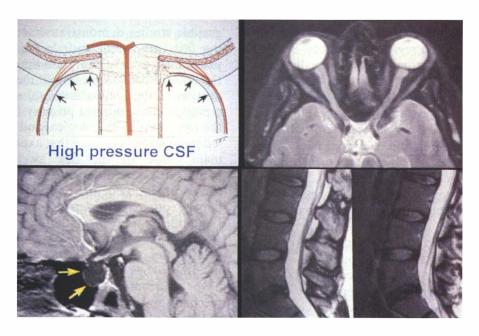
High CSF pressure and the optic nerve sheath. Top left: High CSF pressure distends the distal sheath and fluctuations in pressure can affect branches of the circle of Zinn. Top right: Distended sheath with distal dilatation, acting as an 'expansion vessel', shown on T2-weighted axial MRI scans. Bottom left: Distended pituitary fossa, containing CSF and termed the 'empty sella syndrome'. Bottom right: CSF in the main expansion vessel the 'lumbar sac'.
